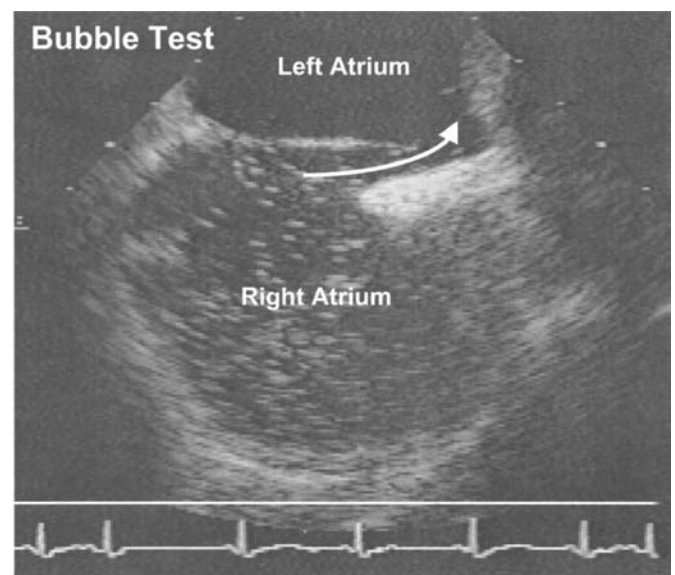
Transesophageal echocardiography at the end of a prolonged Valsalva maneuver in a patient with a patent foramen ovale. An aerated colloid solution was injected into an arm vein containing bubbles that show up as small white dots on the echocardiogram. Some of them clearly cross into the left atrium (arrow) proving the patent foramen ovale.
